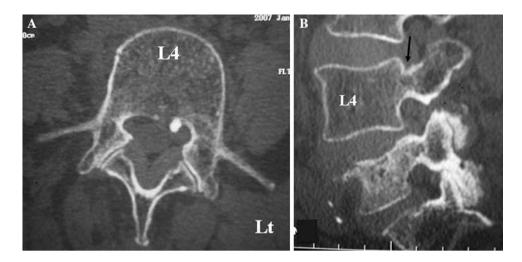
a Computed tomographic (CT) scan demonstrating the bilateral pedicle fracture through L4 (*arrows*). b Parasagittal reconstructions confirm L4 pedicle fractures (*arrow*)
